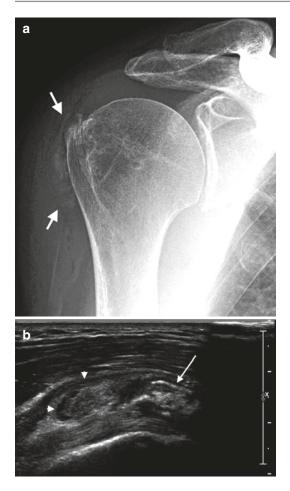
A 52-year-old female drug abuser with severe shoulder pain, ultrasound and radiograph were requested to assess for septic arthritis. (a) AP radiograph demonstrating extensive calcification over the lateral margin of the greater tuberosity and focal calcification within the supraspinatus, (b) ultrasound confirming extensive calcification within the SASD bursa (*arrow*) with complex fluid and synovitis (*arrowheads*). No joint effusion present; the patient had severe tenderness over the bursa and supraspinatus tendon in keeping with acute calcific bursitis
